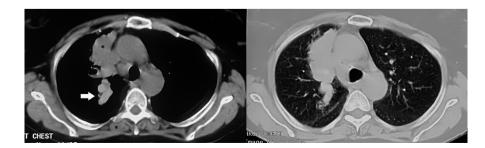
Computed tomography of the chest (mediastinal windows, right panel) showing high-attenuation mucus (broad arrow). The mucus is visually denser than the paraspinal skeletal muscle (asterisk). There is also mucus plugging (isodense or hypodense, asterisk) and collapse of the anterior segment of the right upper lobe. The corresponding lung window is shown in the left panel.
